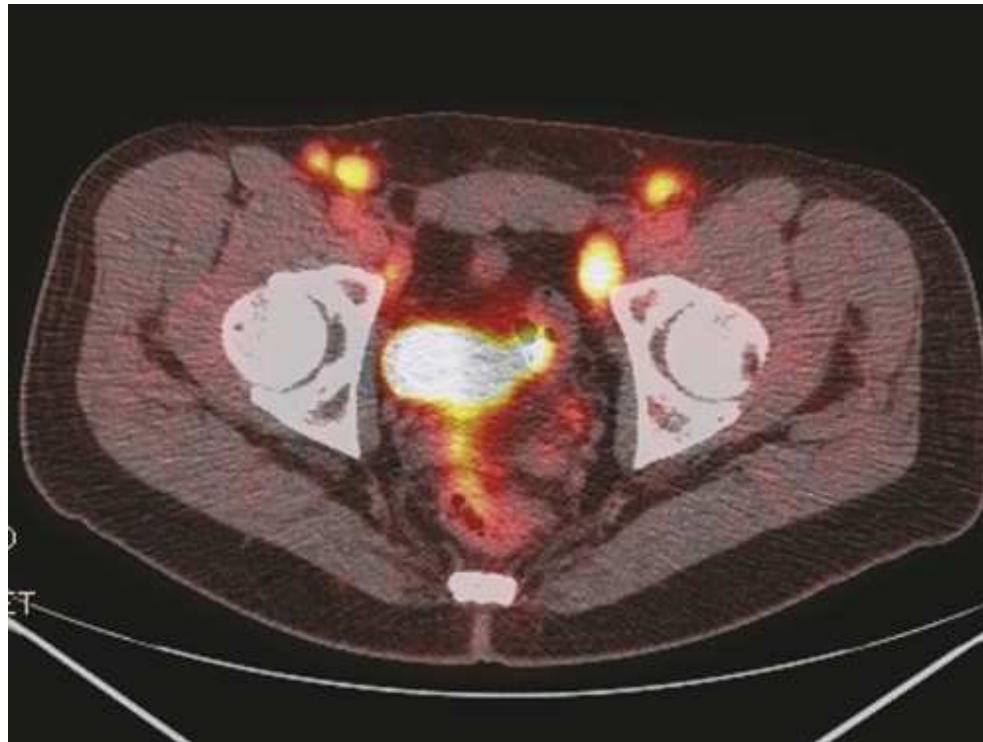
Axial PET/CT of lymph nodes with lymphoma.
